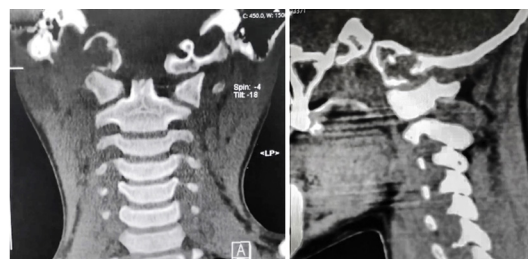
CT coronal (A) and sagittal (B) imaging planes, soft-tissue window, showing a single osteolytic lesion centred on right occipital condyle.
